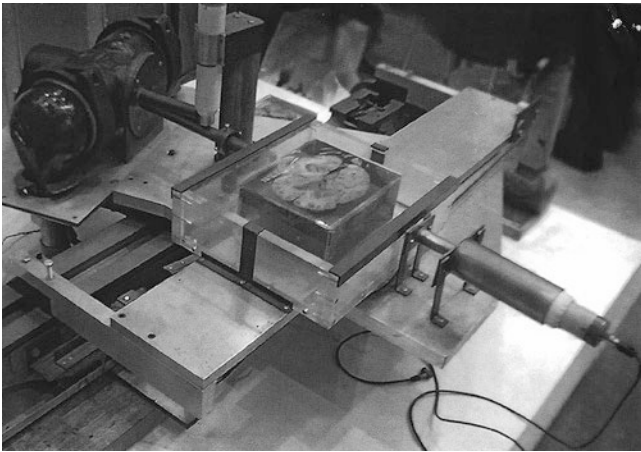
Hounsfield's prototype for the CT scanner. Note the section of brain in the centre of the image
